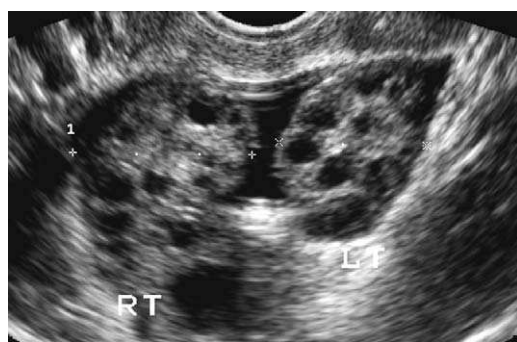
A 24-year-old woman with infertility and polycystic ovary syndrome. Transvaginal sonography demonstrates that both ovaries are round and contain 10 to 12 small follicles and an echogenic stroma, consistent with the diagnosis.
